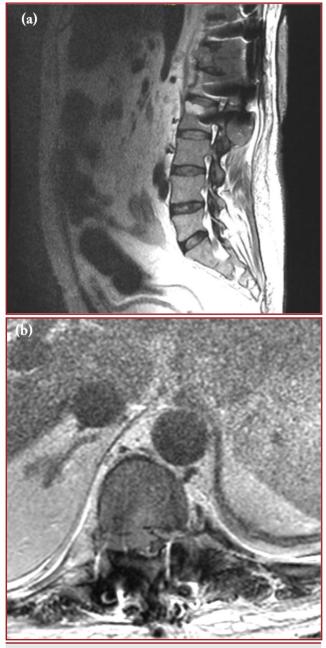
a) Sagittal and b) axial MR imaging of the patient with sepsis. Abscess formation was seen in the paravertebral area. Complete damage of spinal cord has been noticed.
